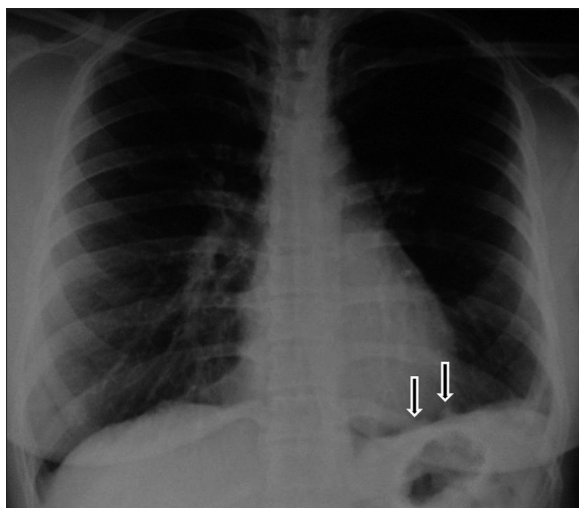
Post-anterior chest X-ray showing the pleura-based nodules (arrows) in the left hemithorax.
